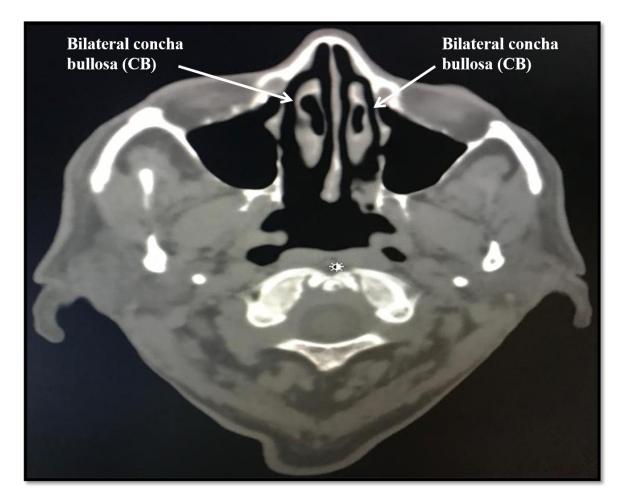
Axial view of CT-PNS showing bilateral concha bullosa (CB) in symptomatic patient of sinusitis
